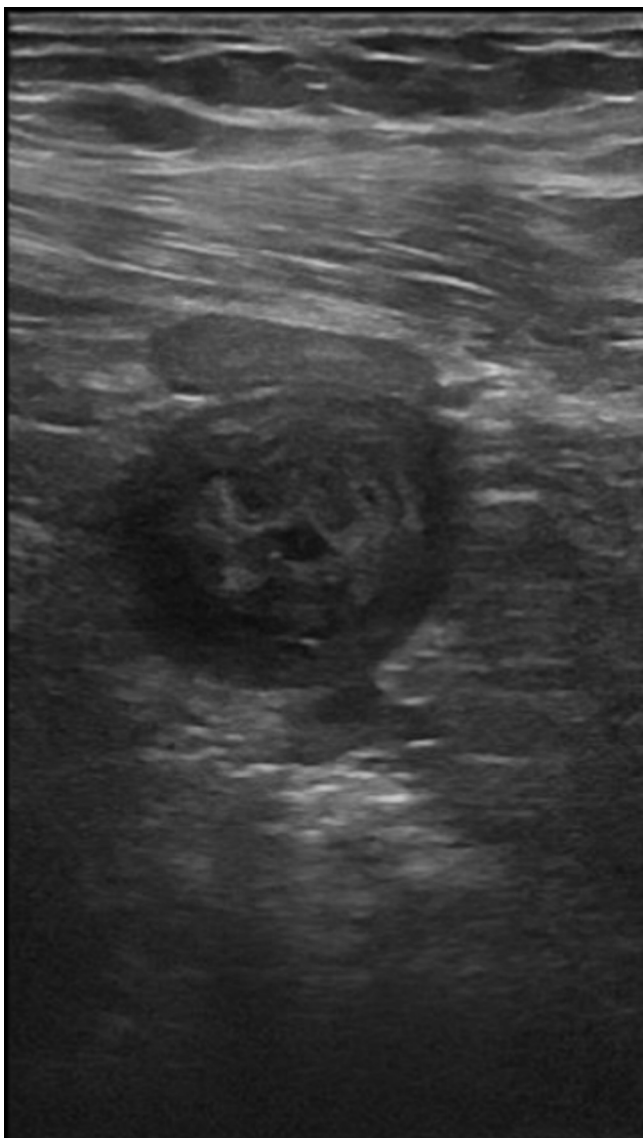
Abdominal ultrasound showing the transversal view of the thickened small bowel.
